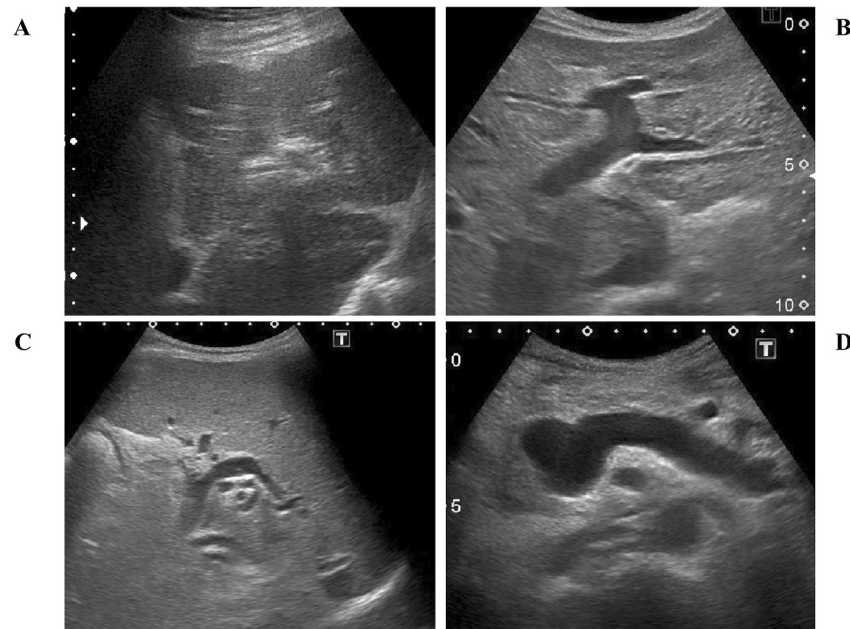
Abdominal ultrasound images in a patient with idiopathic portal hypertension. (A) Epigastric longitudinal scan shows the rippled edge of the left lobe of the liver. (B) Transverse scan of the epigastric area shows a slightly coarsened internal echo in the left lobe of the liver. (C) Subcostal scan of the left costal arch shows splenomegaly. (D) Transverse scan of epigastric area shows an enlarged splenic vein.
